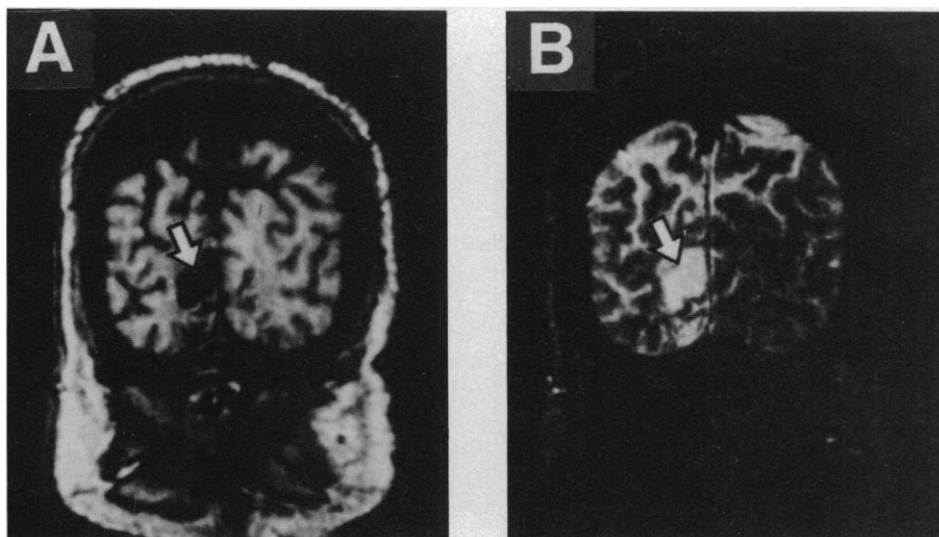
Coronal magnetic resonance images through CLT's occipital lobe (with the left hemisphere imaged on the right). On the T1 weighted image (A) damaged areas appear black or gray. On the T2 weighted image (B), which highlights the water content characteristic of damaged tissue, these areas appear white.
